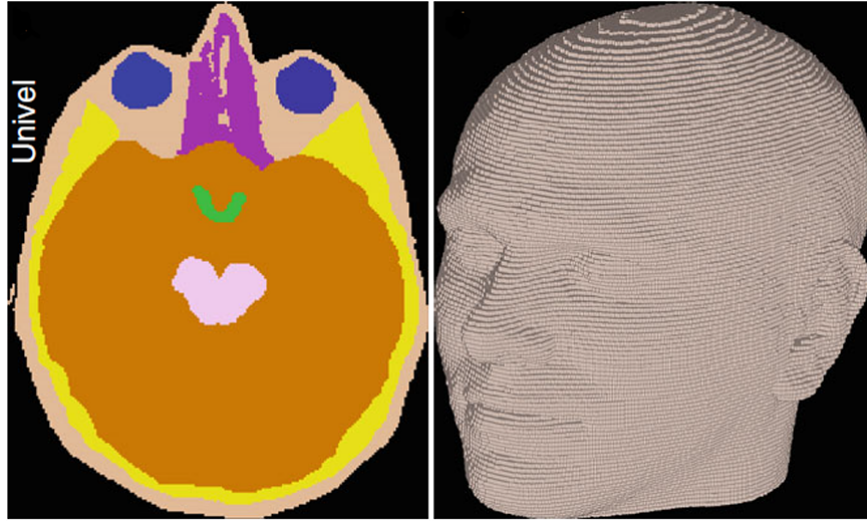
2D slice *Univel* model where air, skin, skull, brain, brain stem, eyes, optic chiasm, and sinuses are defined. Each *univel* corresponds to a pixel in the MR images used to derive the model, which have a pixel size of $1 \times 1 \times 2 \text{ mm}^3$ (left). Right: the corresponding 3D representation [54].
